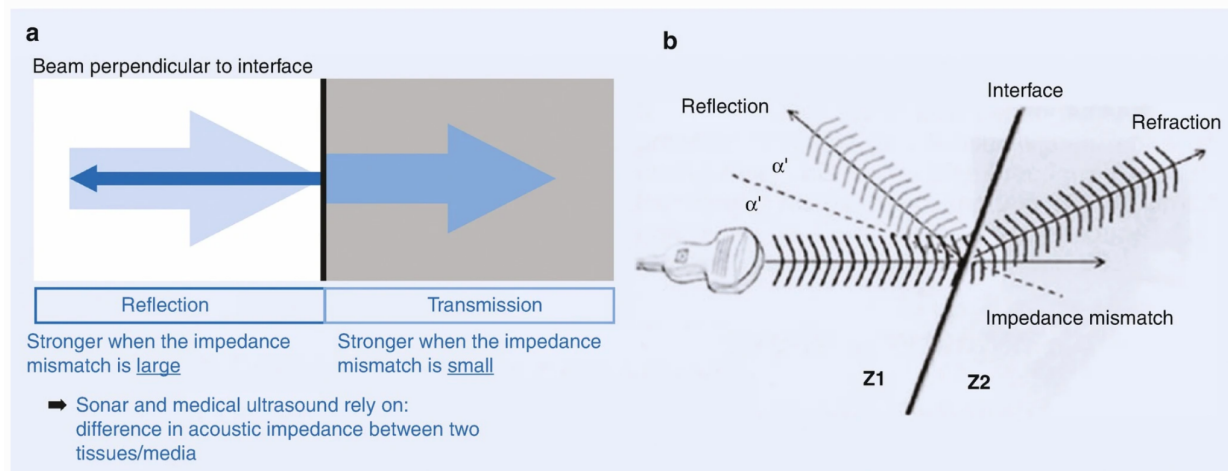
Ultrasound Image. v. a) Generation of an ultrasound image: reflection versus transmission. b) Interaction of ultrasound with interfaces in the body according to the laws of wave optics (Li et al., 2021)
